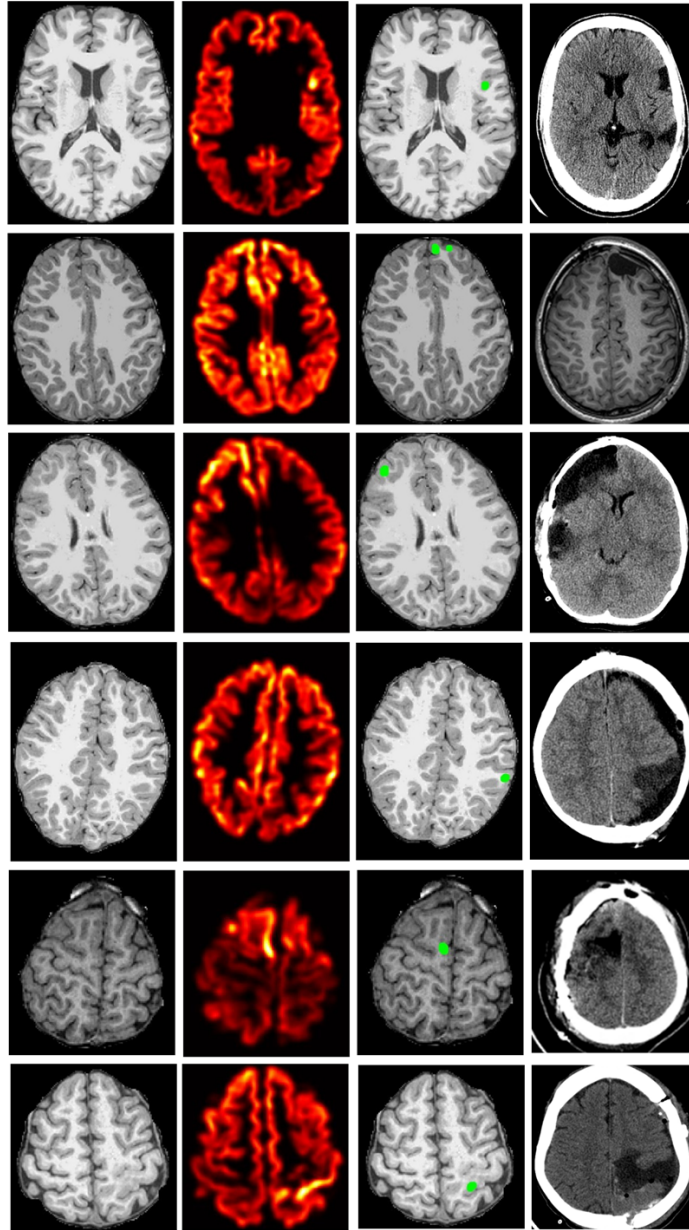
Selected results of volumetric T1 MRI processing using cortical thickness. (Column 1) Original MRI image after normalization and skull stripping , (Column 2) Showing cortical thickness measurements, followed by the application of Gaussian Smoothing and Gamma filtering. Visible cluster of abnormal signal indicates region of lesion. (Column 3) Original image with green overlay indicating vertices identified by program to indicate lesion, (Column 4) Surgical resection site on post-operative CT or T1 scan. Scan indicating location of lesion was removed
